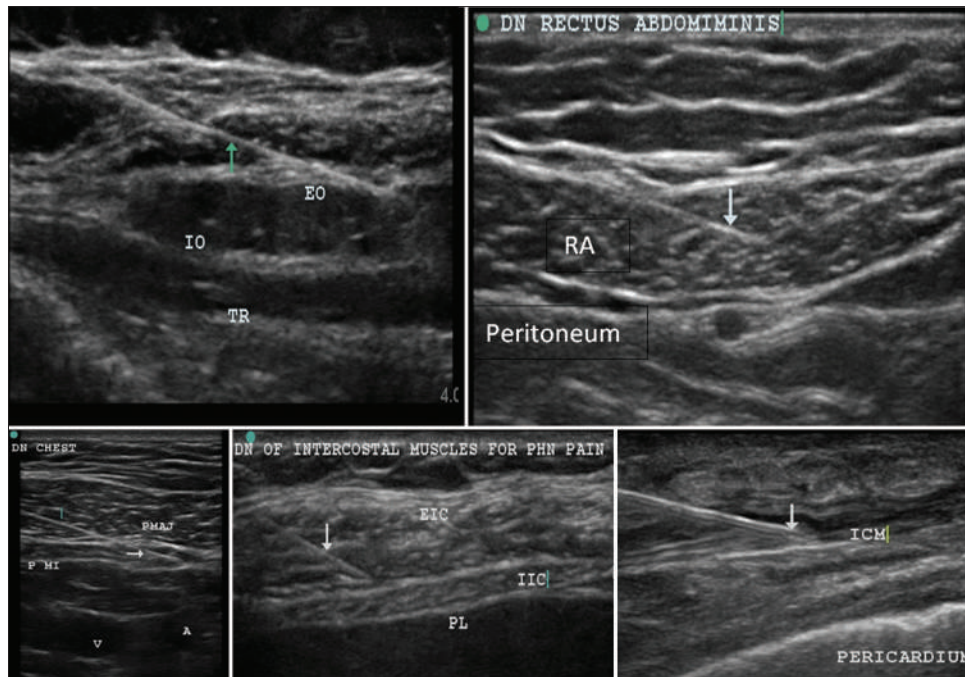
Advantages of ultrasound visualization and the necessity for ultrasound visualization during dry needling. Ultrasound images showing needling of abdominal wall muscles (*top left and right*), chest wall muscles (*bottom left*), and intercostal muscles (*bottom middle and right*). Ultrasonography allows direct visualization of pleura, peritoneum, pericardium, and neurovascular structures so that needles can be steered into muscles while safeguarding these vital structures. EO, external oblique; IO, internal oblique; TR, transversus abdominis; DN, Dry needling, RA-rectus abdominis; PMAJ, Pectoralis major; P MI, Pectoralis minor; V, subclavian vein; A, subclavian artery; PHN, post-herpetic neuralgia; EIC, external intercostal muscle and the muscle superficial to it is the serratus anterior; IIC, internal intercostal muscles; PL, pleura, ICM-intercostal muscle
